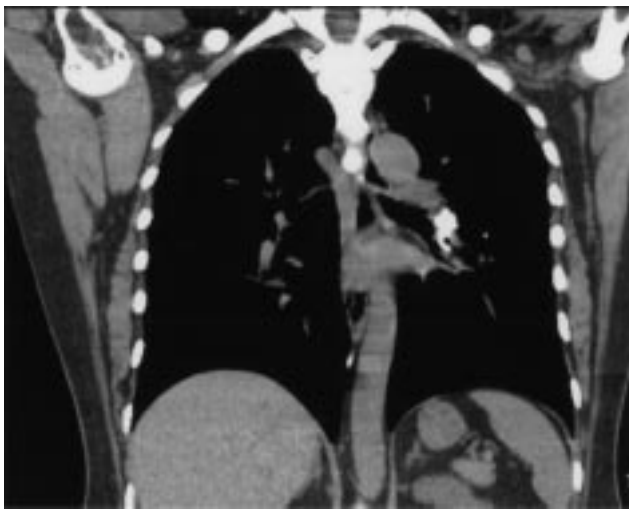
The chest computed tomography (CT) scan demonstrated left interlobar lymph node calcification, near the interlobar pulmonary artery, and its calcification continued into the left basal bronchus.
